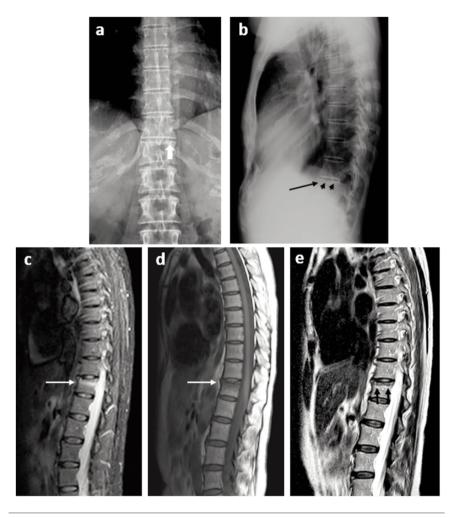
AP (a) and lateral (b) spine X-rays on the date of injury of a patient that had an undiagnosed fracture. It shows loss of definition of superior endplate of the  $12^{th}$  thoracic vertebra (white arrow in a), anterior cortical disruption (black arrow in b), and anterior wedging (black arrowheads in b). Those findings were not identified in the emergency department. MRI (9 days after the accident): Sagittal STIR (c), T1 (d) and T2 (e). Images show a band-like bone marrow edema in the superior endplate of  $12^{th}$  thoracic vertebra (arrows in c and d) and a defined line of fracture (black arrows in e).
